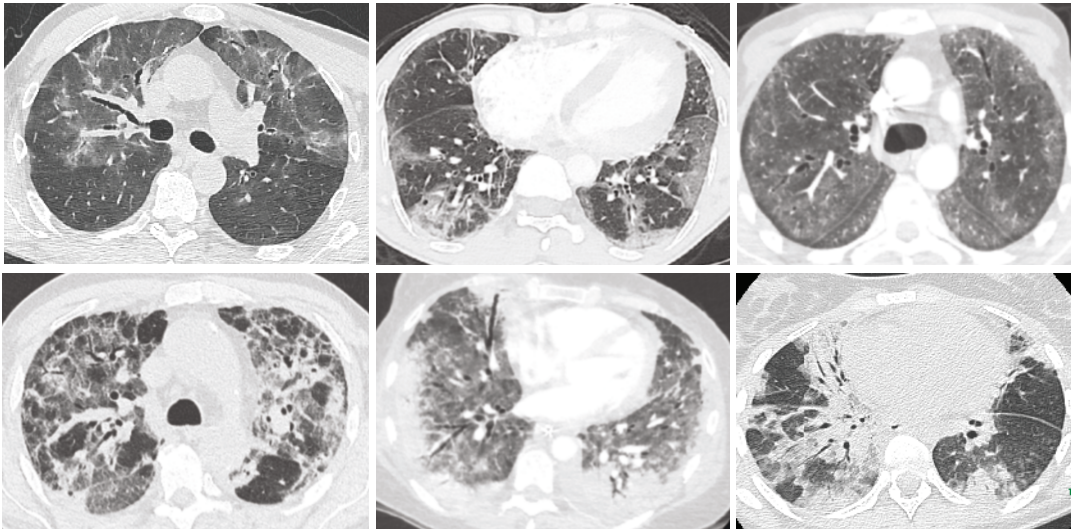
Chest CT images in late-onset noninfectious ILDs after allogeneic hematopoietic stem cell transplantation
